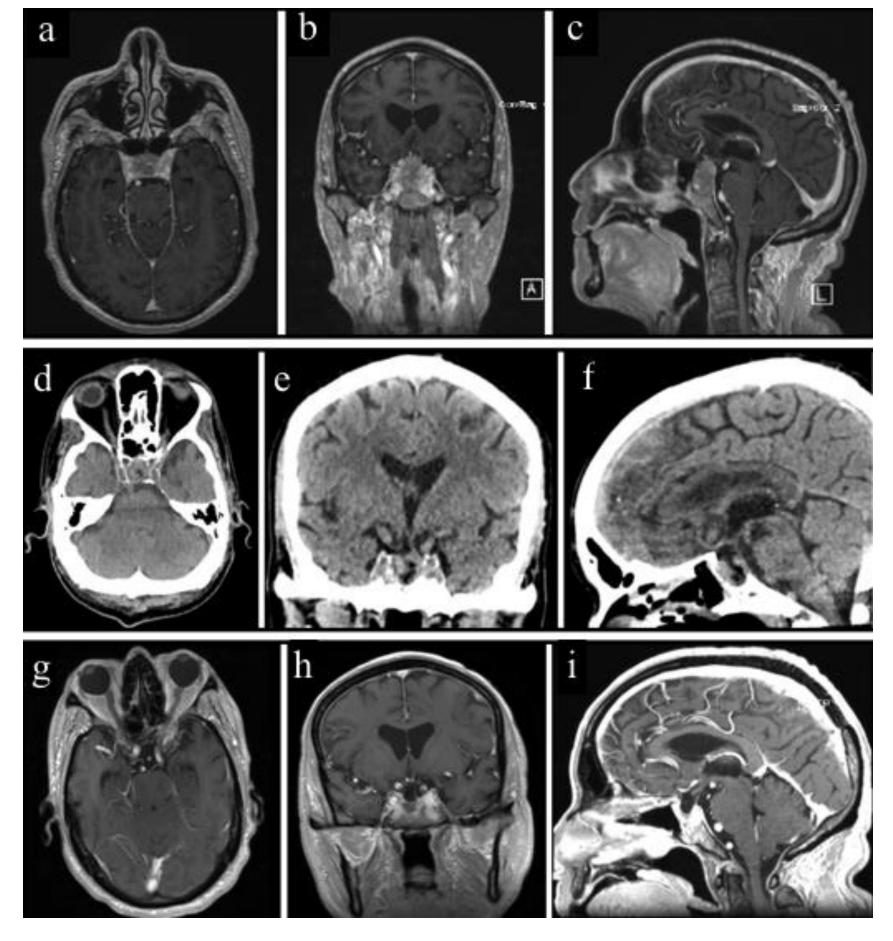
Case 2 pre-operative MRI (T1-weighted, axial, coronal, sagittal views) reveals a $26 \times 16 \times 19$ mm heterogeneously enhancing sellar/suprasellar mass (a, b and c). Post-operative CT shows no bleeding, pneumocephalus, or complications (d, e and f), while post-operative MRI confirms gross total resection of the tumor (g, h and i).
